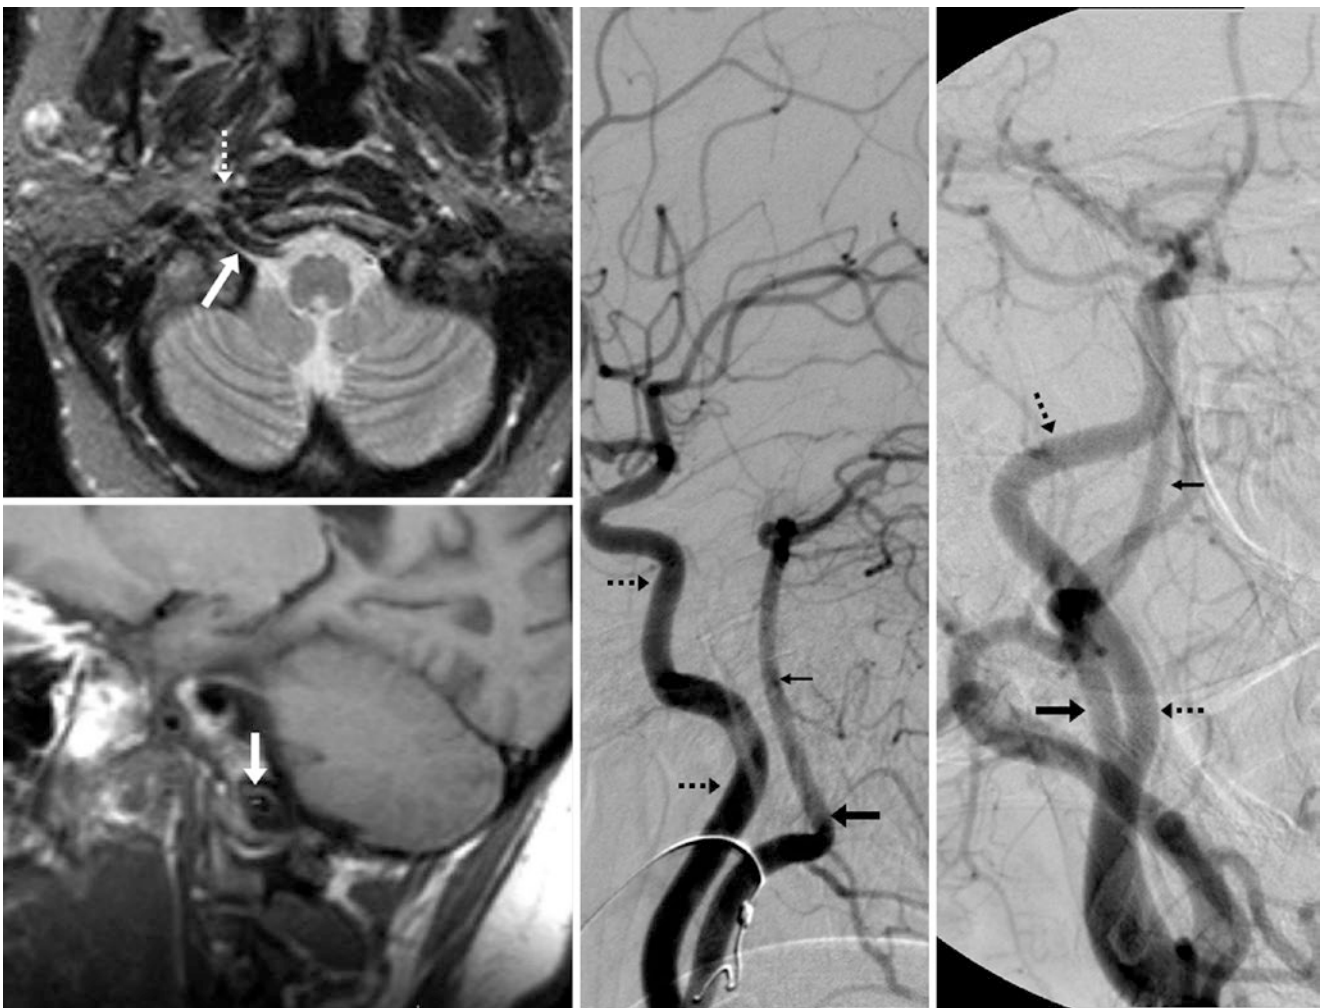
In this 37-year-old, an axial T2WI MRI (top left) and a sagittal T1WI (bottom left) show a persistent hypoglossal artery (PHA, arrows) that connects the right ICA (dotted arrow) to the basilar artery (thin arrows) via the right hypoglossal canal, as shown on lateral
